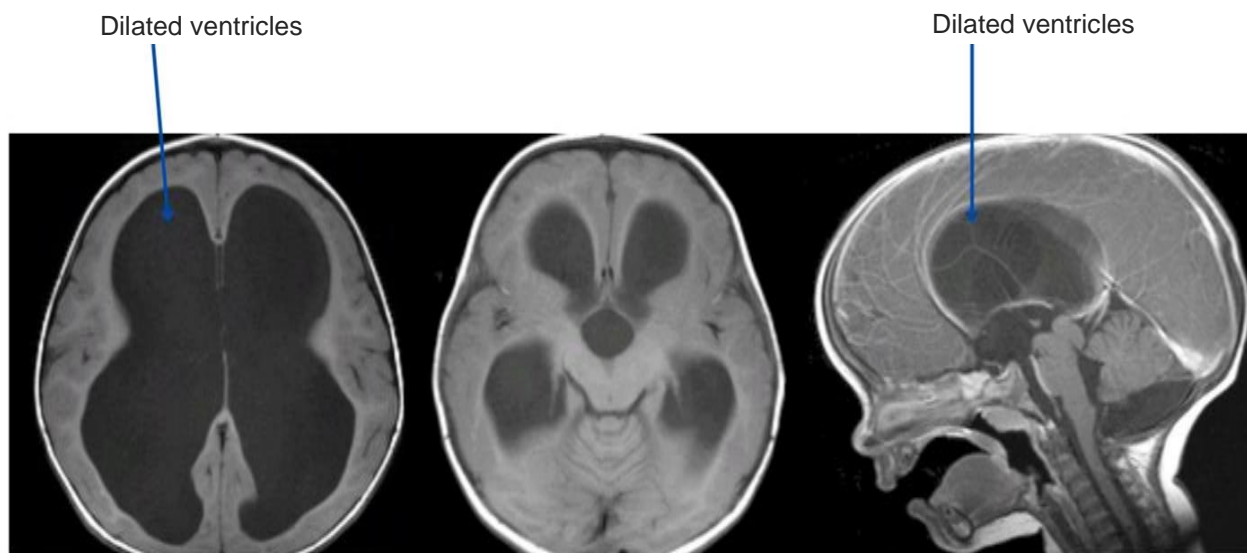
MRI Images of Hydrocephalus in one year old male subject obtained in the present study
